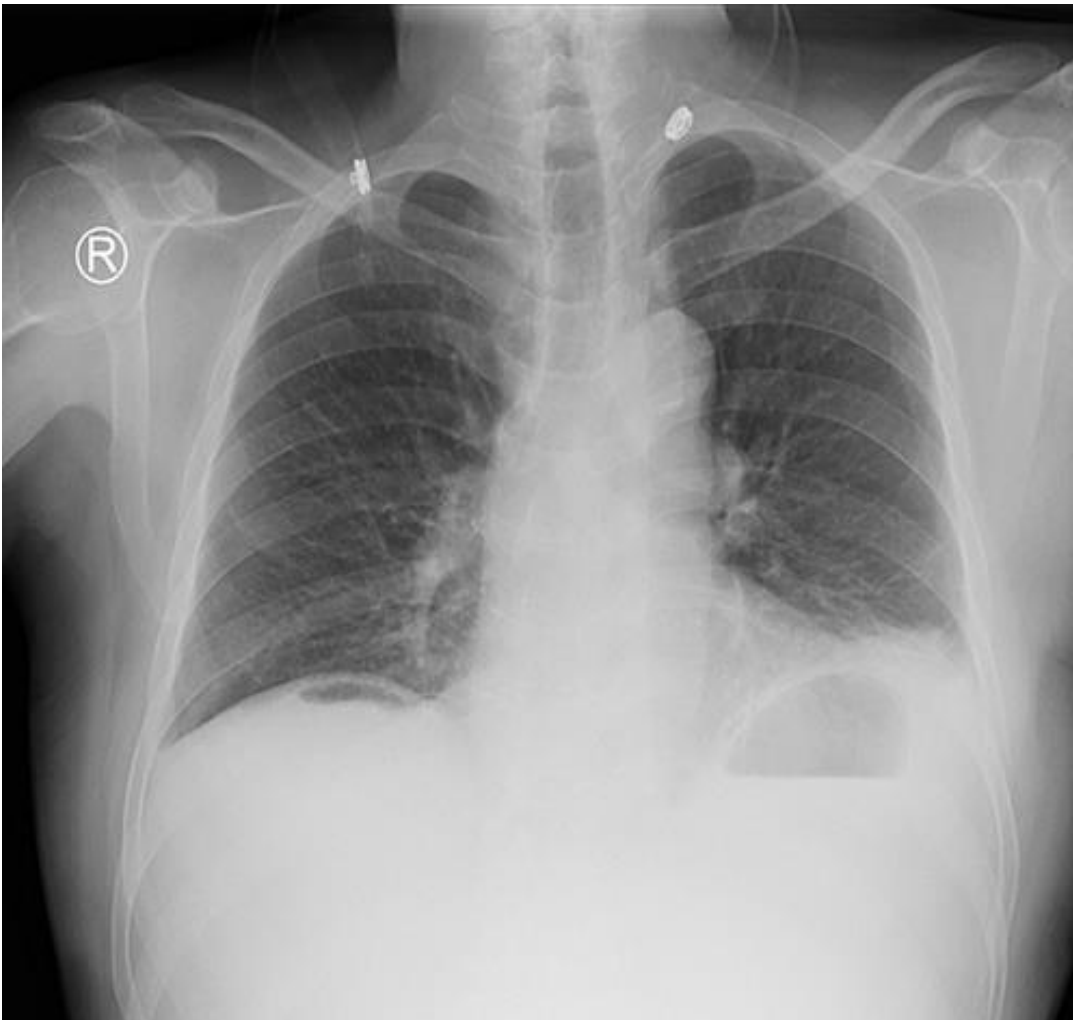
chest X-ray showing air under the diaphragm
